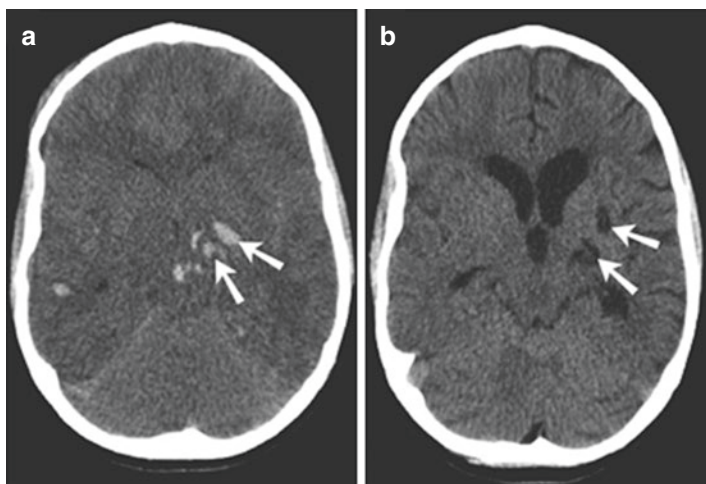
CT scan showing early and late appearance of left basal ganglia and external capsule contusions. Note the right temporal contusion also in the early scan. In the late scan the contusion has resolved leaving behind low-density cavity
